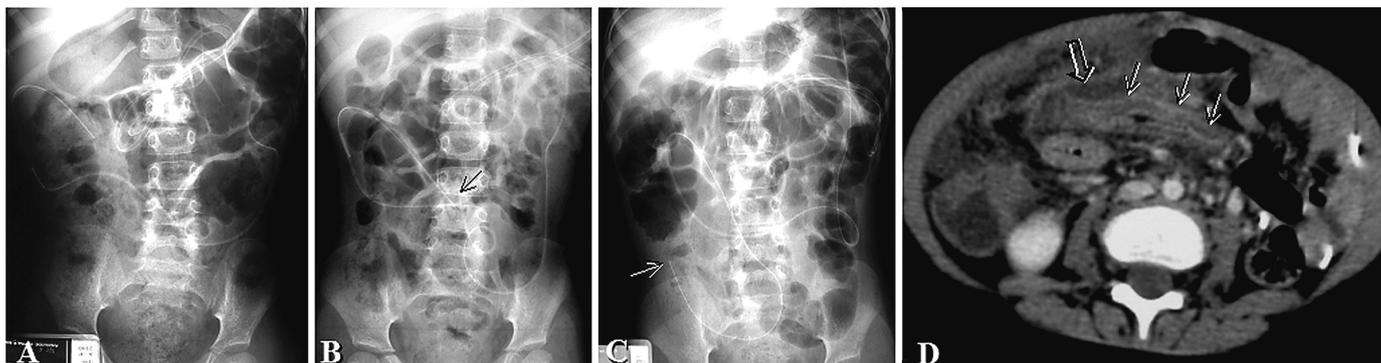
Patient 4. Five-year-old female with epidermolysis diagnosed at birth, complicated with staphylococcal meningitis and septated hydrocephalus requiring two peritoneal shunts. Shunt on left side of abdomen was last revised in January 2003. A, postoperative abdomen radiograph obtained in January 2003, after last shunt revision. B, systematic abdomen radiograph obtained in May 2003 showing that, whereas the revised catheter was free in the left part of the peritoneal cavity, the right catheter was stuck in the right part of the abdomen (arrow). C, in October 2003, the child was hospitalized again for
